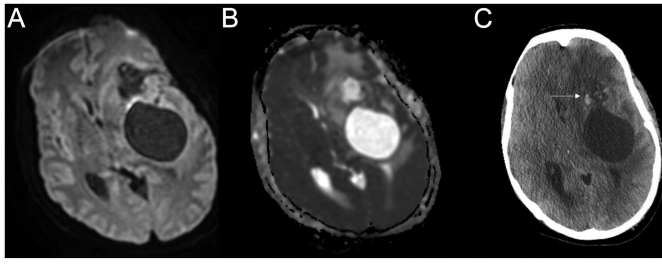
In diffusion-weighted and ADC MR images of a 44-year-old man, a large left temporal cystic/solid lesion with mass effect and compression of the left cerebral peduncle was detected. Solid and hemorrhagic elements on anterior margin (C) (arrow), which do not exhibit restricted diffusion (A, B). Moderate vasogenic edema more pronounced anteriorly. Pathology results confirm GBM in this patient. ADC, apparent diffusion coefficient; GBM, glioblastoma multiforme; MR, magnetic resonance.
